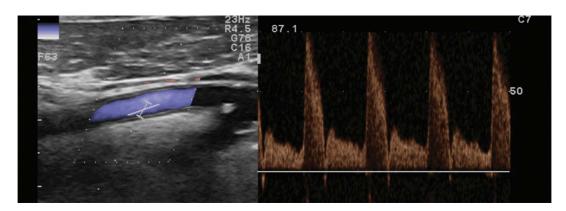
External carotid artery waveform. Doppler sonogram shows external carotid artery that supplies high-resistance vascular beds of osseous and muscular structures of head and neck; thus, waveform is characterized by sharp rise in flow velocity during systole, rapid decline toward baseline, and diminished diastolic flow. Adapted from Figure 68.7 of Sprynger M, et al. Vascular echo imaging. In: Lancellotti P, Zamorano JL, Habib G, Badano L, eds. *The EACVI Textbook of Echocardiography*. 2nd ed. Oxford, UK: Oxford University Press; 2016.
